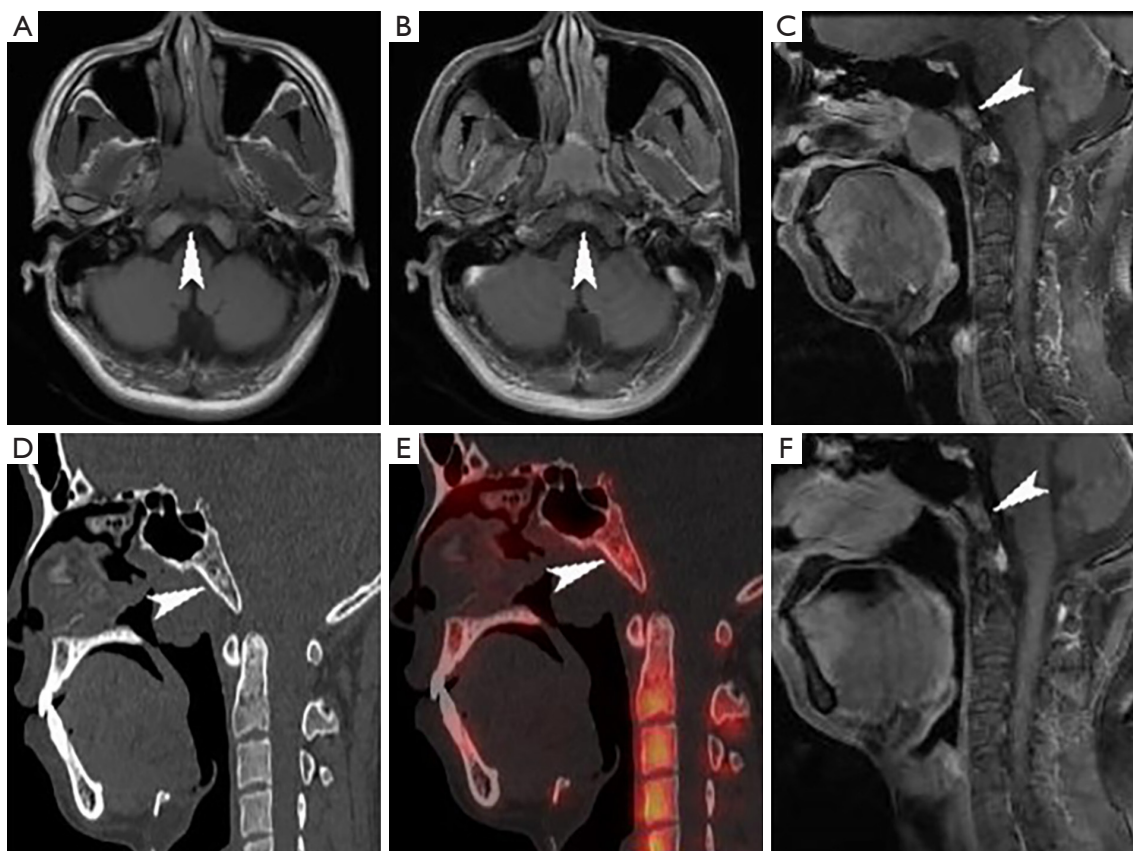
Images of a 29-year-old man with NPC. (A) MRI-T1WI images (arrowhead) revealed local hypointensity in the clivus. (B) Cross-sectional T1WI enhancement (arrowhead) and (C) sagittal T1WI enhancement (arrowhead) further indicated local enhancement, leading to a presumptive diagnosis of SBBI. (D) Sagittal CT (arrowhead) imaging demonstrated irregular increased density of the clivus. However, (E) the ^{18}F -NaF PET/CT fusion image (arrowhead) did not exhibit definite abnormal radiological activity at the corresponding site, suggesting a benign bone lesion when ^{18}F -NaF PET/CT was integrated with MRI findings. (F) A follow-up MRI 6 months later showed localized enhancement at the clivus (arrowhead), with no significant change compared to the initial MRI examination, ultimately confirming the diagnosis as a benign bone lesion. NPC, nasopharyngeal carcinoma; MRI, magnetic resonance imaging; T1WI, T1-weighted imaging; SBBI, skull-base bone invasion; CT, computed tomography; ^{18}F -NaF PET/CT, ^{18}F -sodium fluoride positron emission tomography-computed tomography.
